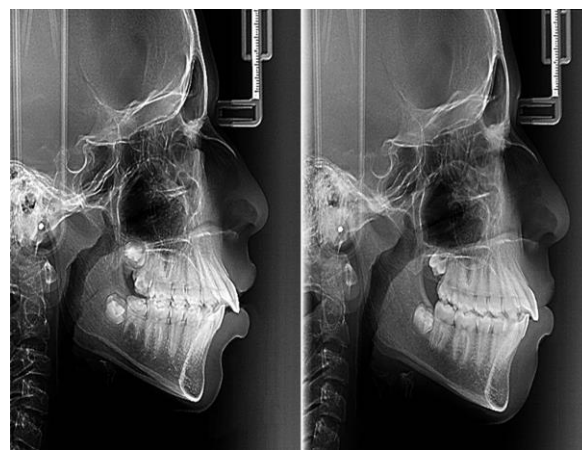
Lateral cephalometric x-rays of a patient before (left) and after (right) treatment
